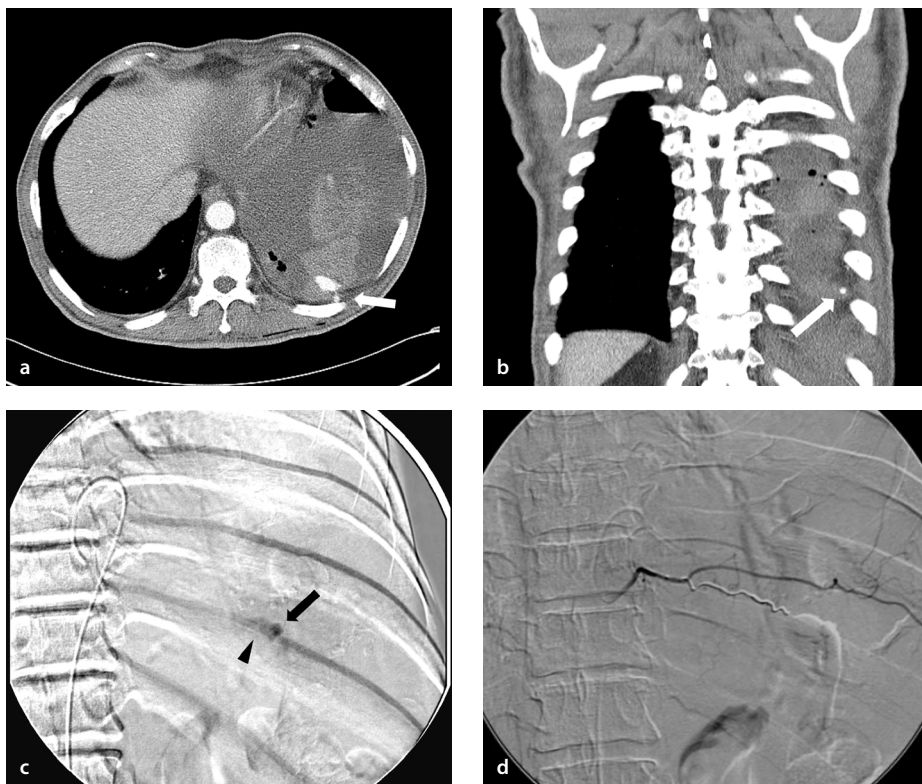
A 69-year-old man (no: 1) developed a hemothorax following a percutaneous thoracic needle biopsy (PTNB) of left pleural tissue. (a, b) Computed tomography images obtained immediately after a PTNB showed a hemorrhagic pleural effusion with extravasation of contrast medium at the left 10th intercostal artery. (c) The left intercostal angiogram showed a definite pseudoaneurysm (arrow) and contrast extravasation (arrowhead) at the left 10th intercostal artery. (d) The bleeding focus was embolized using two microcoils, and the completion angiogram showed no further bleeding.
